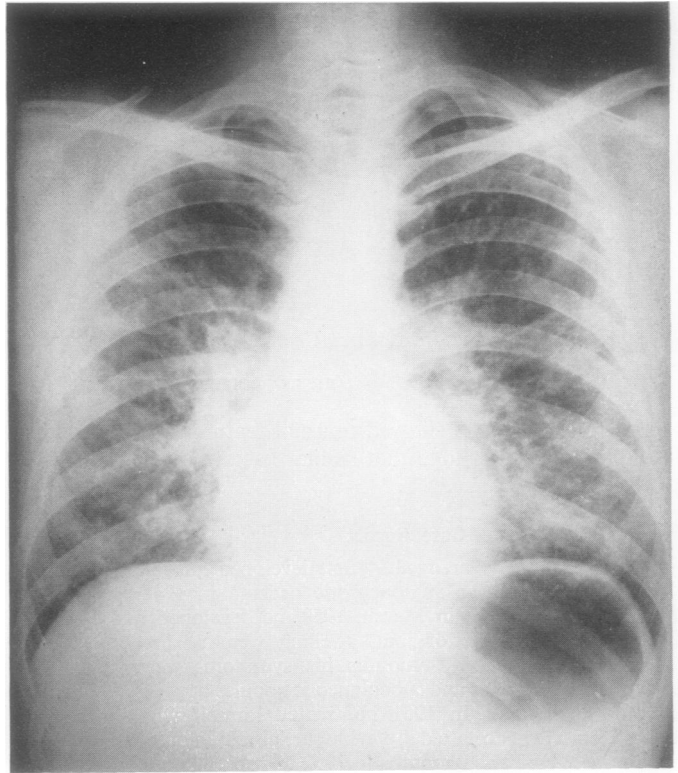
(a).—Postero-anterior chest radiograph, October, 1955.
